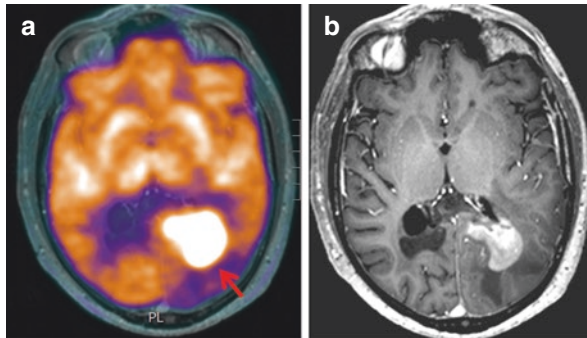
Axial fused ^{18}F FDG PET/MR (a) and post contrast T1WI (b) demonstrates intense increased FDG uptake in the periventricular region of the posterior horn of the left lateral ventricle (a, arrow) which corresponds to an enhancing lesion on the post contrast MR (b), in a patient with CNS lymphoma
